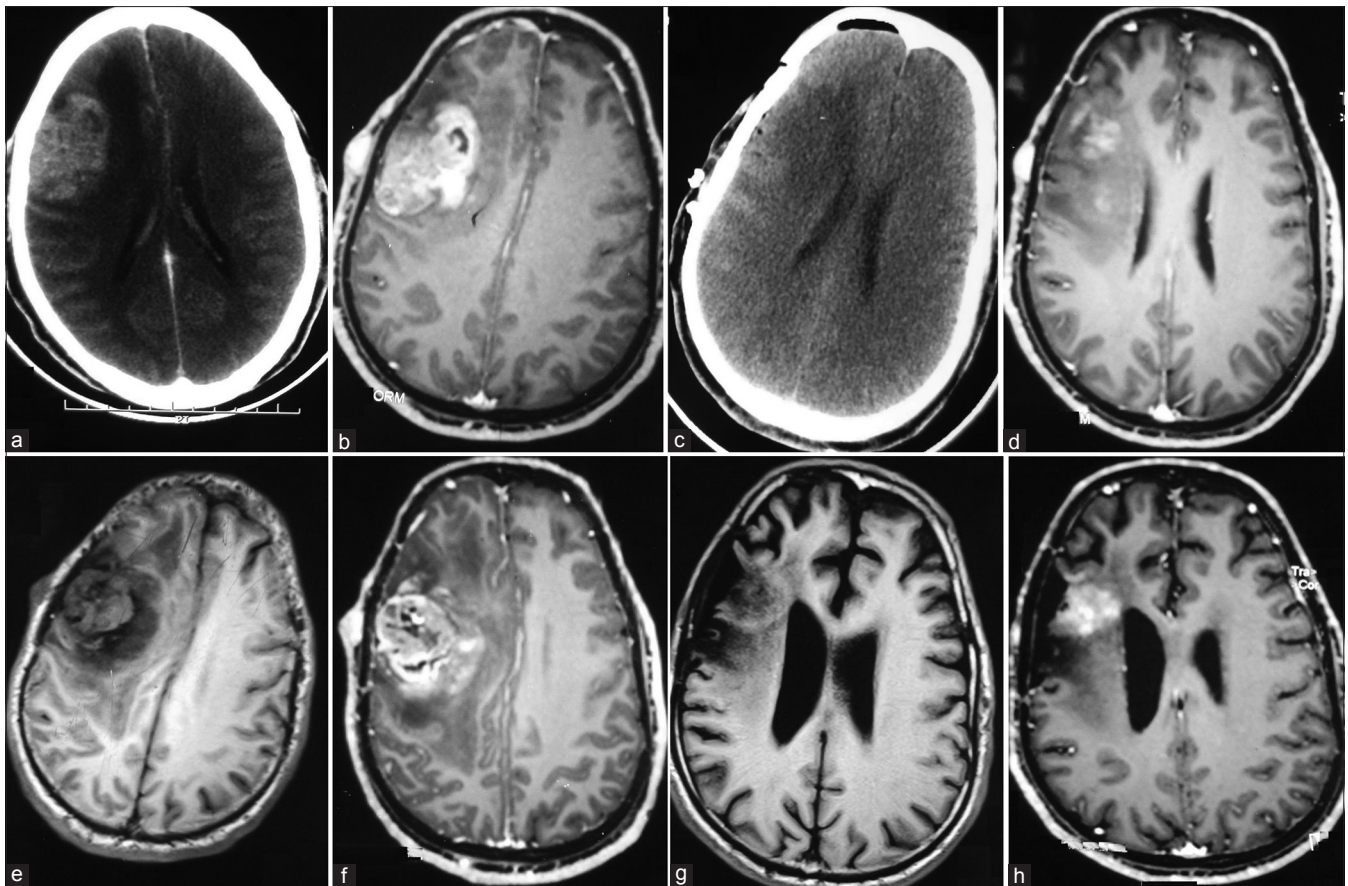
Preoperative axial noncontrast computed tomography head and axial magnetic resonance imaging T1-weighted contrast image showing right frontal peripherally located, well-circumscribed lesion hyperdense on computed tomography and dense contrast enhancing on magnetic resonance (a and b). Postoperative noncontrast computed tomography head (c) showing total excision. At 1-year follow-up axial magnetic resonance imaging (d) showing gliosis. At recurrence, the lesion had focal necrosis and surrounding edema on T1-weighted contrast (e and f). Imaging at 3-year follow-up showing minimal area of enhancement at previous operated site and no evidence of edema (g and h)
